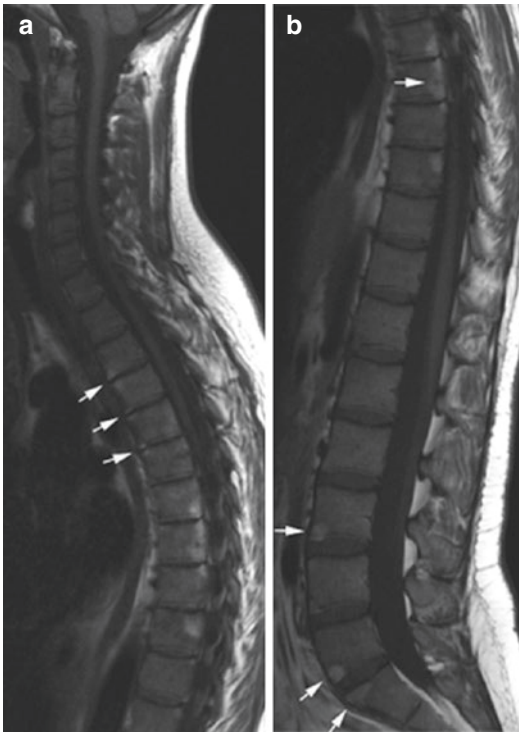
Chronic (post-inflammatory) AS. Sagittal, T1-weighted images of the (a) cervicothoracic and (b) lumbar spine demonstrate fatty marrow changes at the vertebral entheses (arrows) [6]
